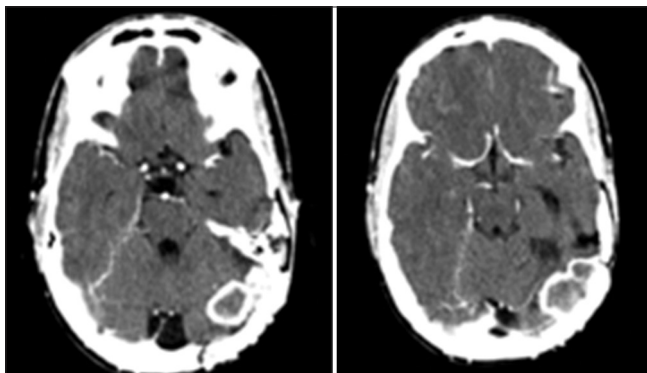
Axial head CT-scan with contrast showing tumor recurrence 20 months after the second surgery
